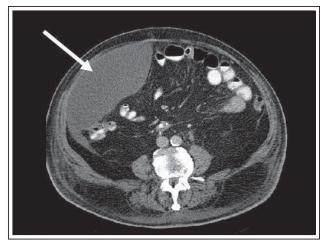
CT scan showing collection of urine adjacent to abdominal wall (indicated by white arrow).
